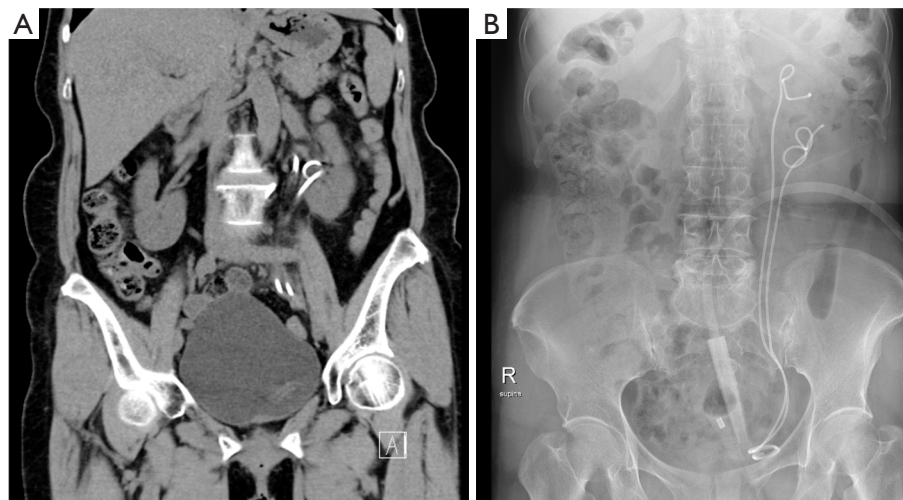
Postoperative follow-up (A) computed tomography image showing no residual stone and (B) X-ray showing intact double-J stents placed in the duplicated ureters.
